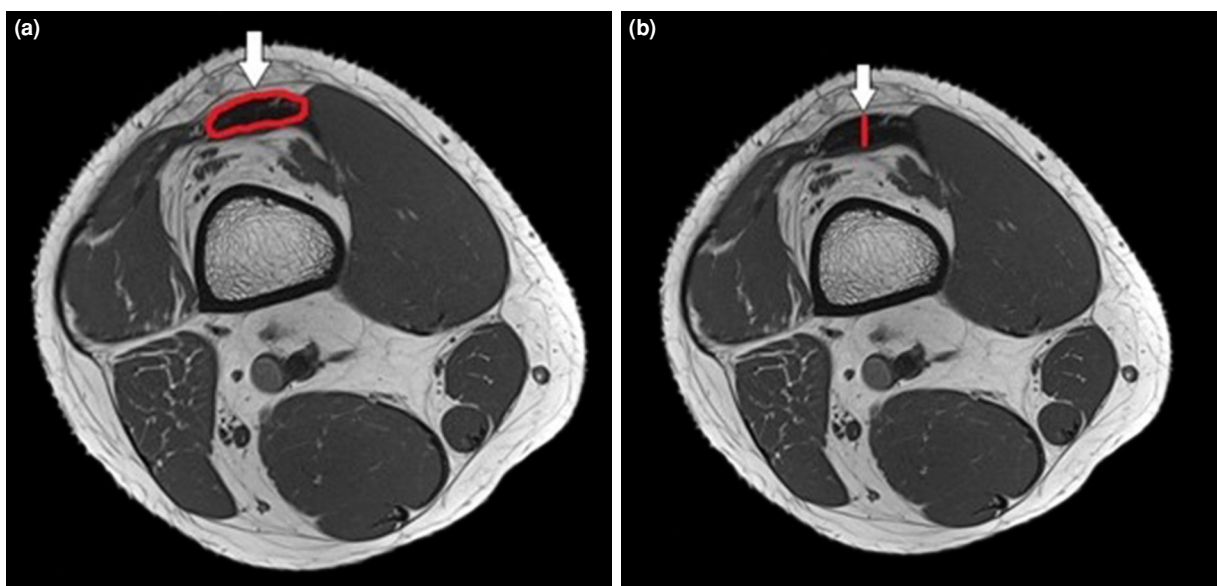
Transverse turbo spin-echo T1-weighted knee-magnetic resonance images of the quadriceps tendon. (a) Quadriceps tendon cross-sectional area. (b) Quadriceps tendon thickness.
